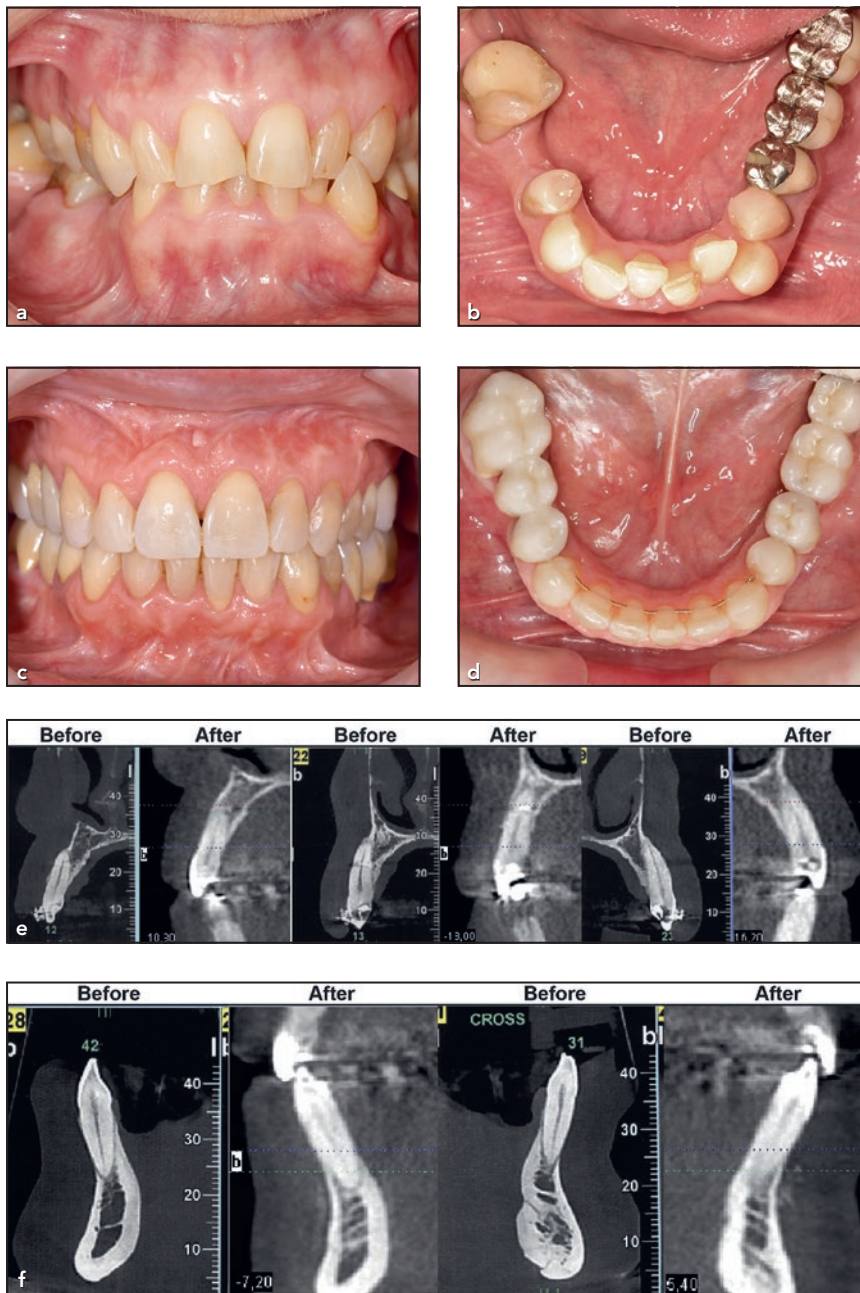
Case 3. (a) Buccal and (b) mandibular occlusal views at the beginning of treatment. (c) Buccal and (d) mandibular occlusal views at the end of treatment. (e) CBCT radiographs before and (f) after treatment. Note that no root exposure outside the cortical bone is noticeable despite the transversal expansion of both arches.
